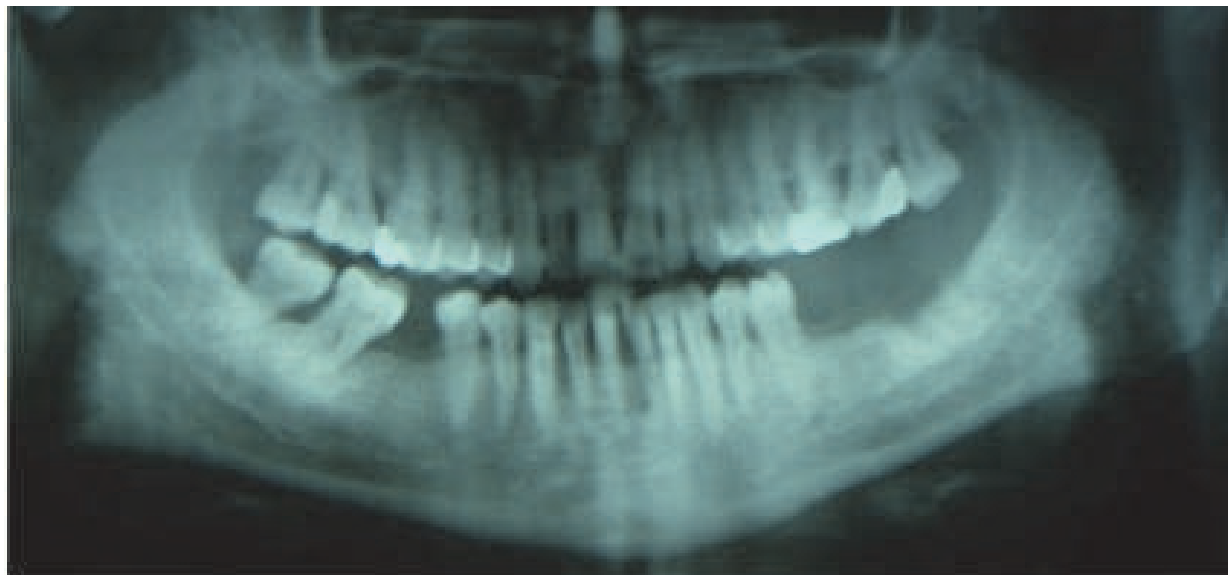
Preoperatif panoramic radiograph.
